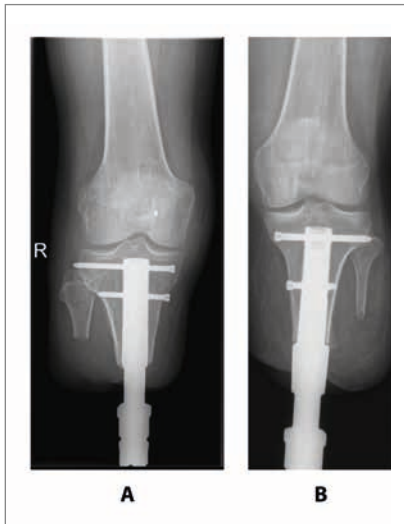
Anteroposterior radiograph of implant with internal (a) and external (b) taper connection.
